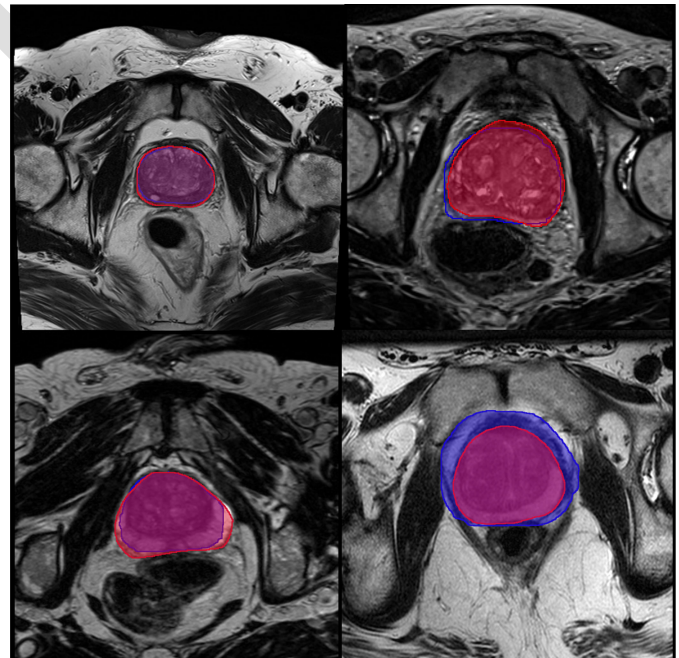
MRI segmentation of the prostate. Images are taken from different patients. PROST-Net results are in blue; the ground-truth is in red.
